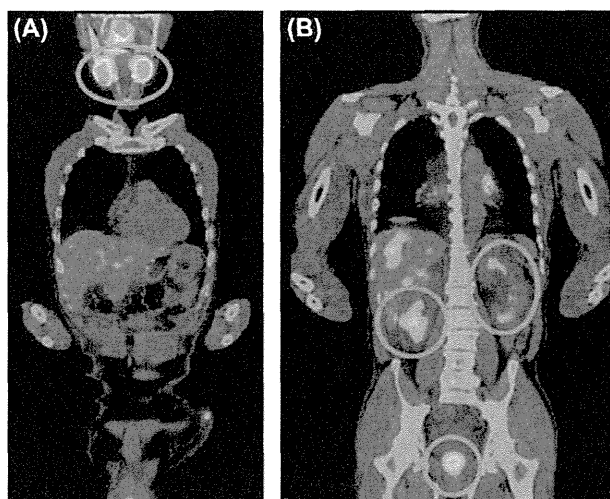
Gallium scintigraphy findings before treatment. Significant accumulation of gallium was observed in the bilateral submandibular glands, the bilateral kidneys and the prostate. Red circled sites demonstrate positive uptake lesions.
